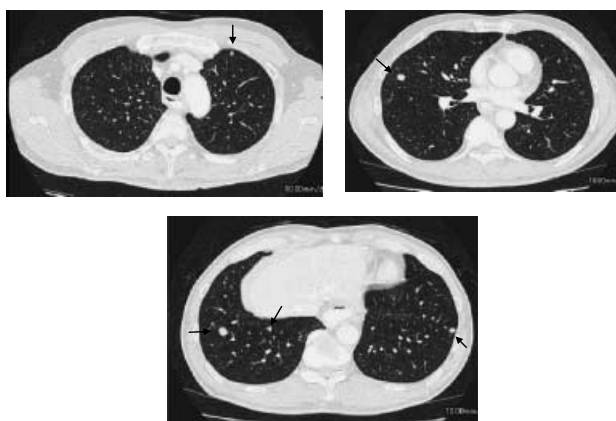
CT finding after 2 weeks of DFP therapy showing slight reduction in the size of lung tumors (arrows)
